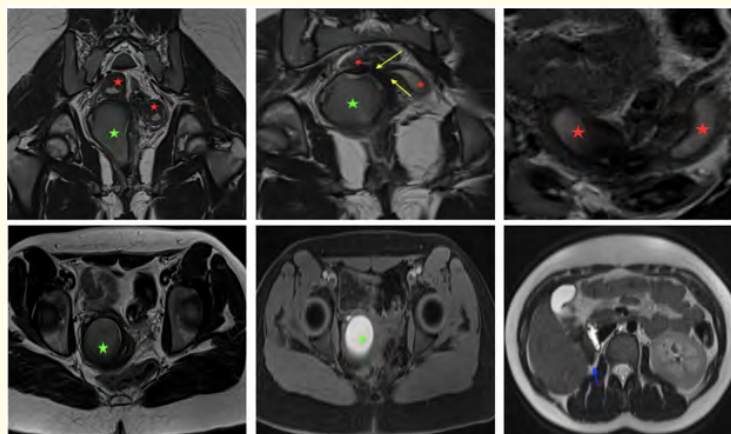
Pelvic MRI in a 14-year-old girl, menarche 8 months earlier, presenting with dysmenorrhea. The study shows two uterine cavities (red asterisks) with two cervixes (yellow arrows) and a vagina divided by a right-sided obstructing longitudinal septum, causing hematocolpos (green asterisk). Right renal agenesis is also present (blue arrow). Overall, the findings are consistent with a complete bicorporeal uterus (U3b), double cervix (C2), and an obstructing longitudinal vaginal septum (V2) - an OHVIRA configuration - complicated by right-sided hematocolpos.
